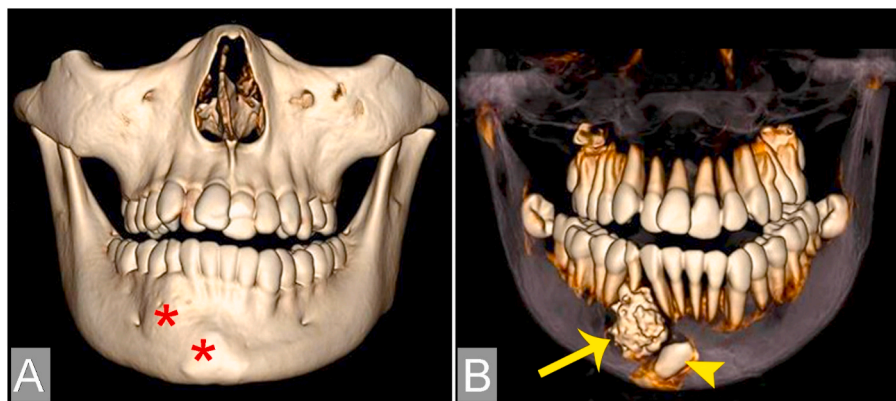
(A) On the 3D-reconstruction CT image, the position affected by lesions of the mandible is bulging (asterisks). (B) CT 3D-reconstruction image after bone-removal shows more clearly the 3D structure of the lesion with the mass of odontoma (arrow) and the 4.3 impacted tooth is retained and displaced (arrowhead).
